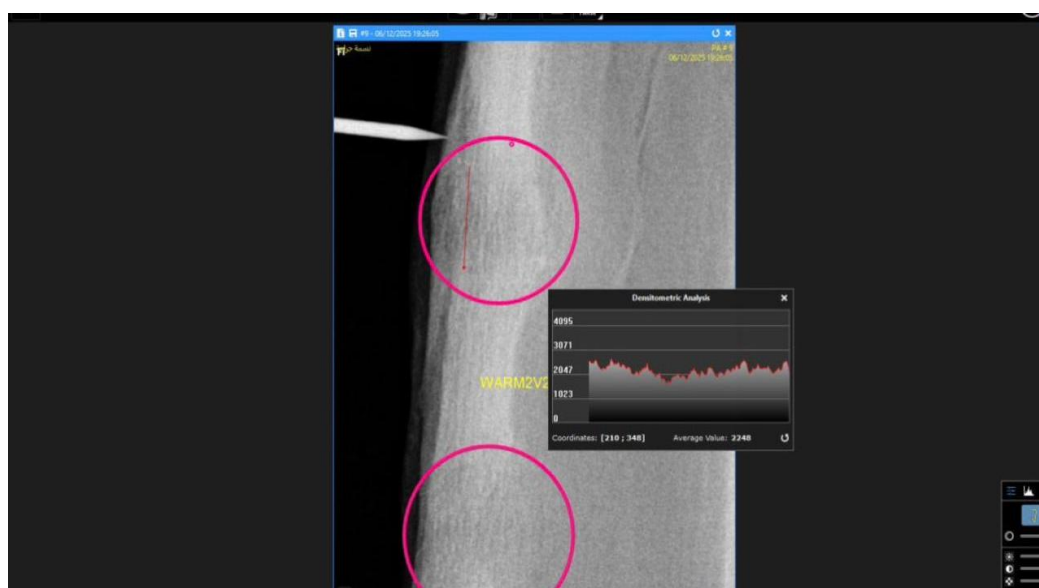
Radiographic densitometric screenshot labelled WARM2V2, showing circled radiographic fields and a higher average value of approximately 2248.
